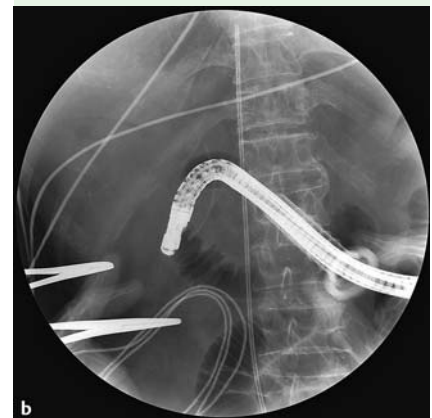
a Duodenoscope being passed through the trocar. b Radiograph showing the duodenoscope reaching the papilla. Note the duodenoscope entering the stomach through the outer sheath of the trocar via the abdominal wall.
